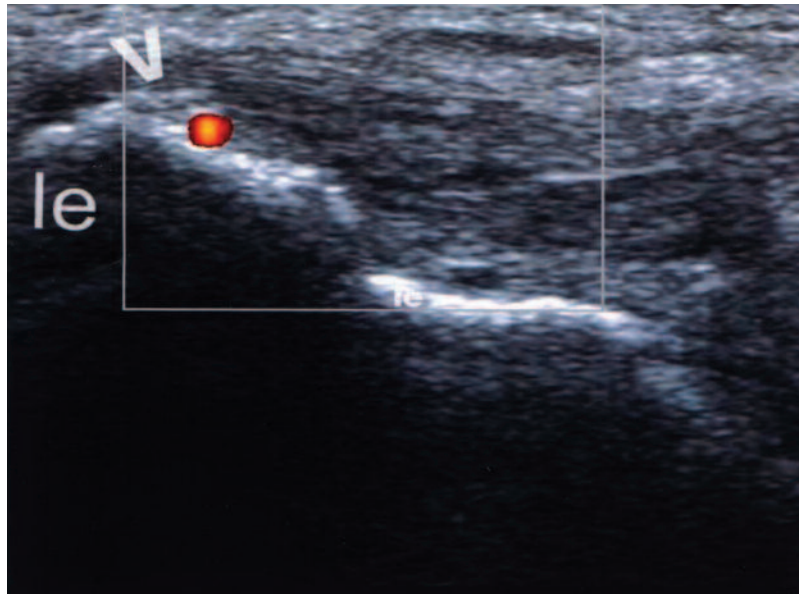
Longitudinal ultrasonography image of the common extensor tendon at the lateral epicondyle of the elbow. The enthesis shows abnormal thickening and hypoechoogenicity, calcific deposits (arrowhead), and intraentheses power Doppler signal. le: lateral epicondyle.
